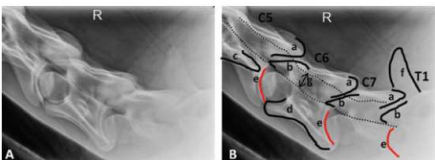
[052]: lateral radiograph of caudal cervical vertebrae (C5, C6, C7, T1): a = caudal articular processes, b = cranial articular processes, c = transverse process of C5, d = transverse process of C6, e = IVD space, f = dorsal spinous process of T1, g = vertebral canal
